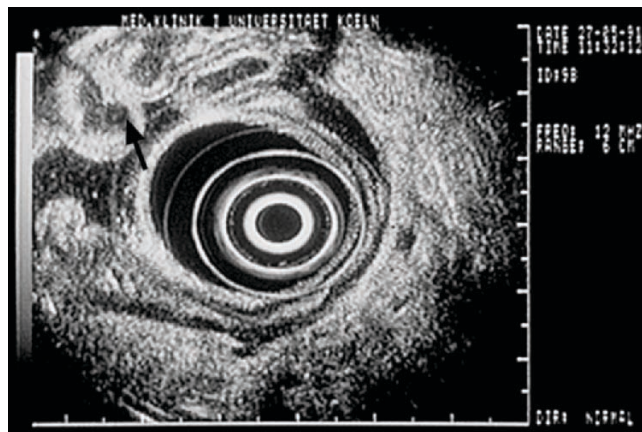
Endosonographic detection of fundus varices (↑)
